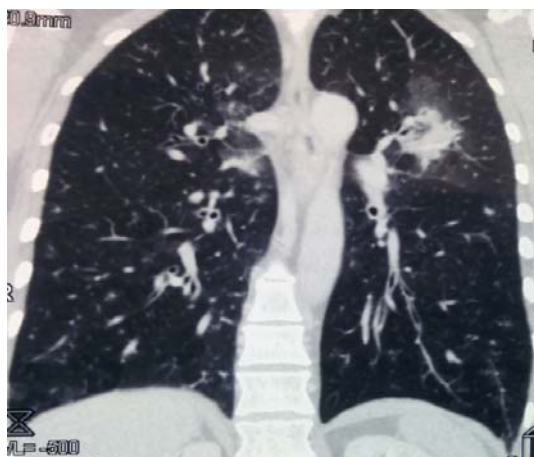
Multislice computed tomography (MSCT) of the chest showing changes in the form of ground glass located in all lobes of the right lung and an infiltrate in the upper lobe of the left lung.
